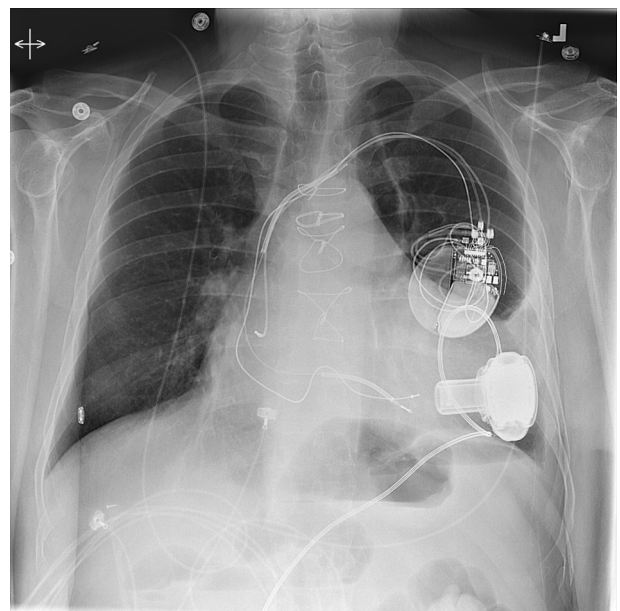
Anteroposterior view of portable chest radiograph (semiupright view) demonstrating HVAD position in the early postoperative period.
